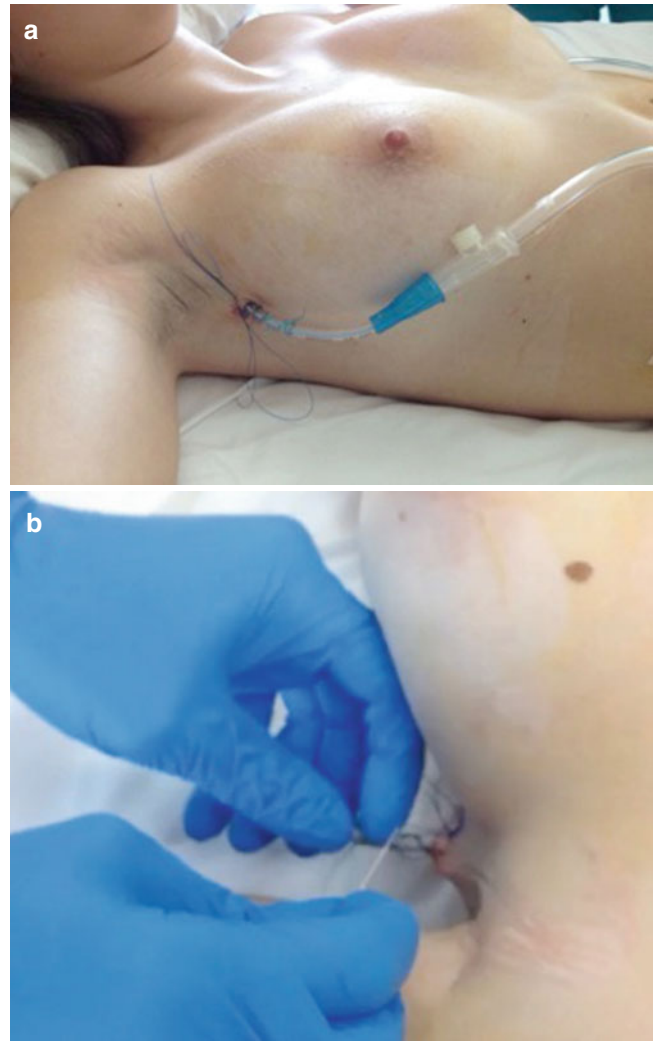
(a, b) Removal of chest drains is performed 2 h after surgery, if a postoperative pulmonary radiograph has excluded the presence of pneumothorax or hemothorax. A #11 blade is used to cut the suture knot tied around the tube; once the knot is untied, the drain on one side is extracted from the chest with a rapid movement. Another operator then immediately ties the knot that was sutured all around the tube, in this way closing the incision
